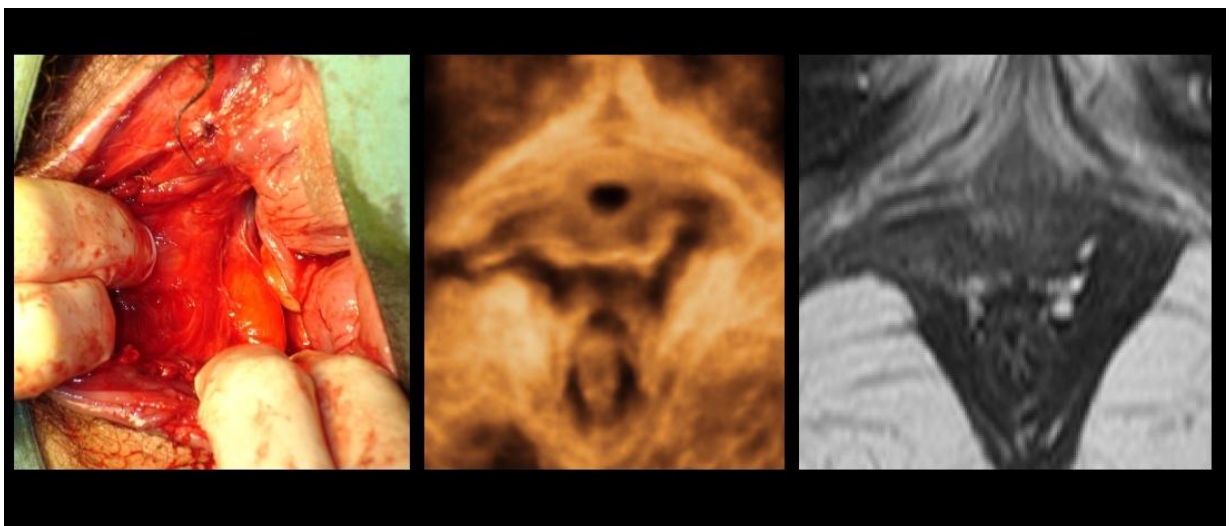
demonstrates an excellent correlation of clinical findings of puborectalis muscle avulsion with 3D ultrasound scan and MRI¹²⁴.
